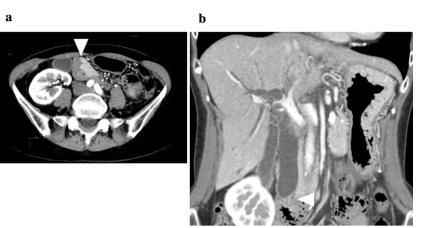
Computed tomography: CT scan confirms a 2 cm, enhanced mass in the periampullary region (arrowhead) and shows marked common bile duct dilatation.
